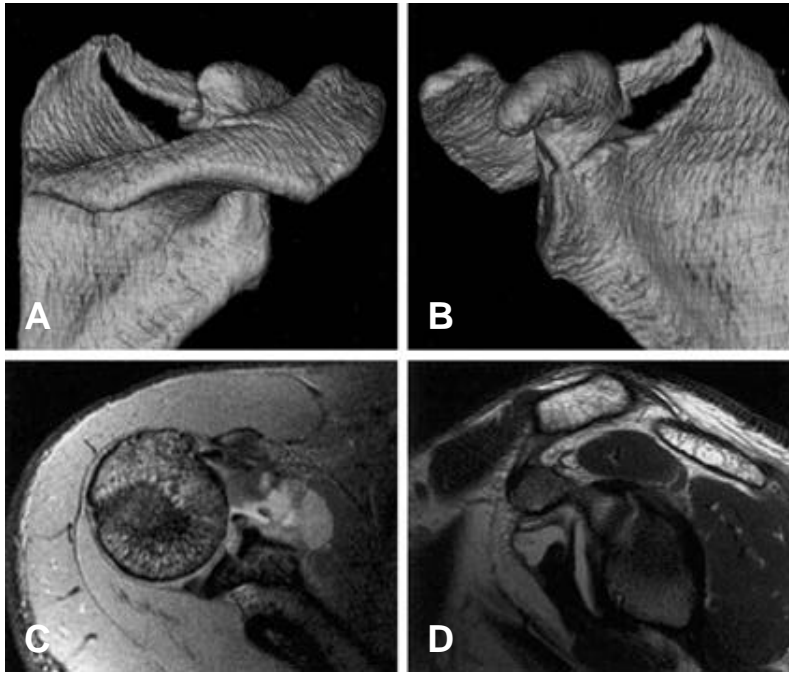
The CT & MRI findings of case 2 (A, B) 3D CT shows minimally displaced acromial fracture & severe displaced coracoid base fracture (C, D) axial & sagittal MRI show high signal of posterior labrum & displaced glenoid fracture.
